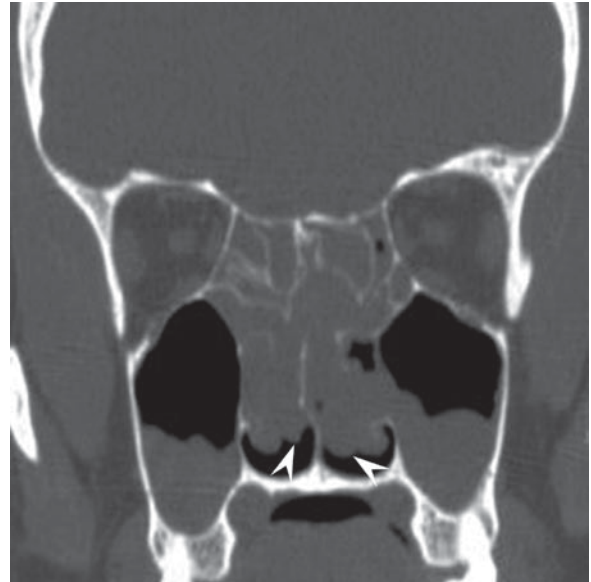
Intranasal convexities in NP. Coronal CT shows numerous convex surfaces (*arrowheads*) along the aerated border of the nasal cavity. This finding suggests polyposis over other sinonasal diseases such as cystic fibrosis
